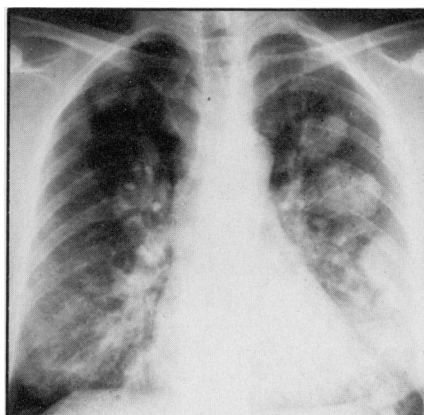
A 1976 chest radiograph revealing increase in size and number of pulmonary nodules.
